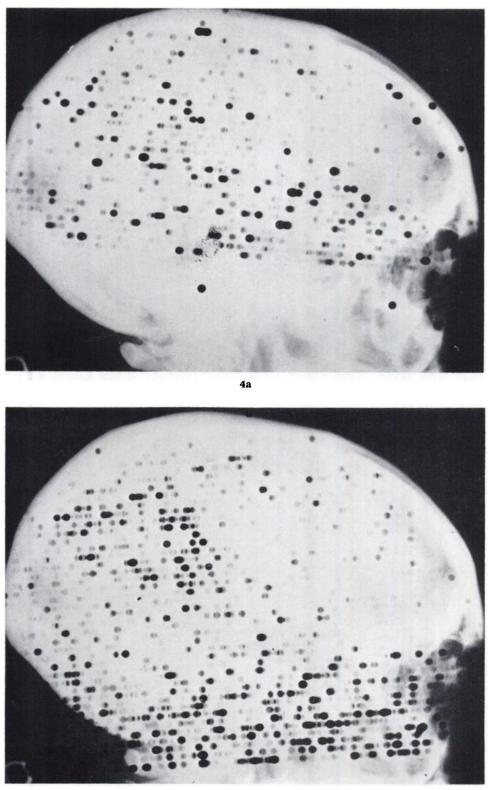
reveals the evolution of a right middle cerebral territory infarct, with Fig. 4a, 16 days post infarct, showing a poorly defined diffuse area of increased uptake forming a wedge from superior to the right ear posteriosuperiorly to blend with the scalp activity. Figure 4b, 42 days post ictus, reveals a smaller, more circumscribed area, again with somewhat indistinct borders, but with greater uptake. Figure 5 represents the scans on a 45-year-old male who entered with the sudden onset of aphasia and a right visual field detect without hemiparesis. Figure 5a is the initial scan performed at the eight day interval. It was felt to be consistent with tumor. Skull x-rays and cerebrospinal fluid studies were normal, and bilateral arteriograms revealed no evidence of tumor, but there appeared to be a partial occlusion of the vessels bilaterally. The scan in Fig. 5b, 33 days post ictus, is suggestive of some minimal residual uptake in the previously abnormal area, but was markedly improved and considered within normal limits.
